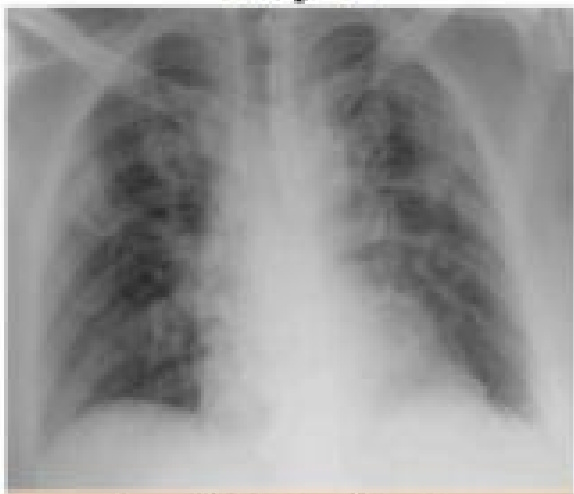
(b) Day 4 lung x-ray of COVID-2019 patient
